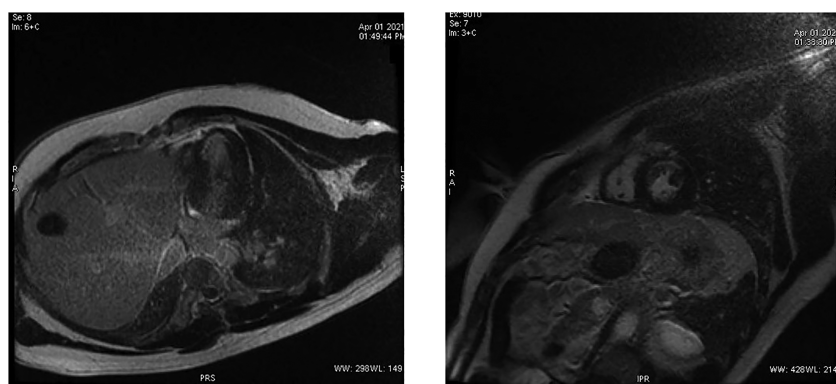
Cardiac magnetic resonance imaging: late gadolinium enhancement in left ventricular septoapical and anteroapical segments.
